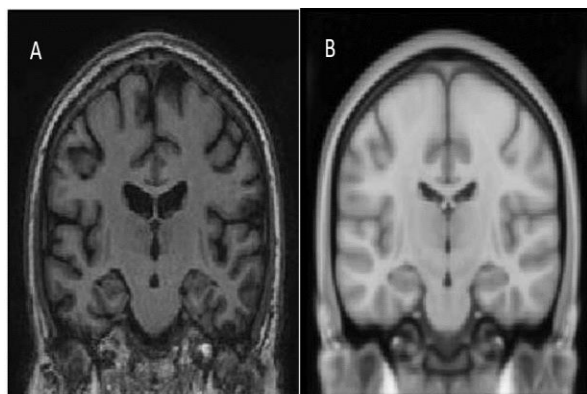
Displayed Data upon check option A) T1-weighted scan co-registered with the MNI template. B) MNI template showing result upon de-selecting the T1-weighted scan in SPM
